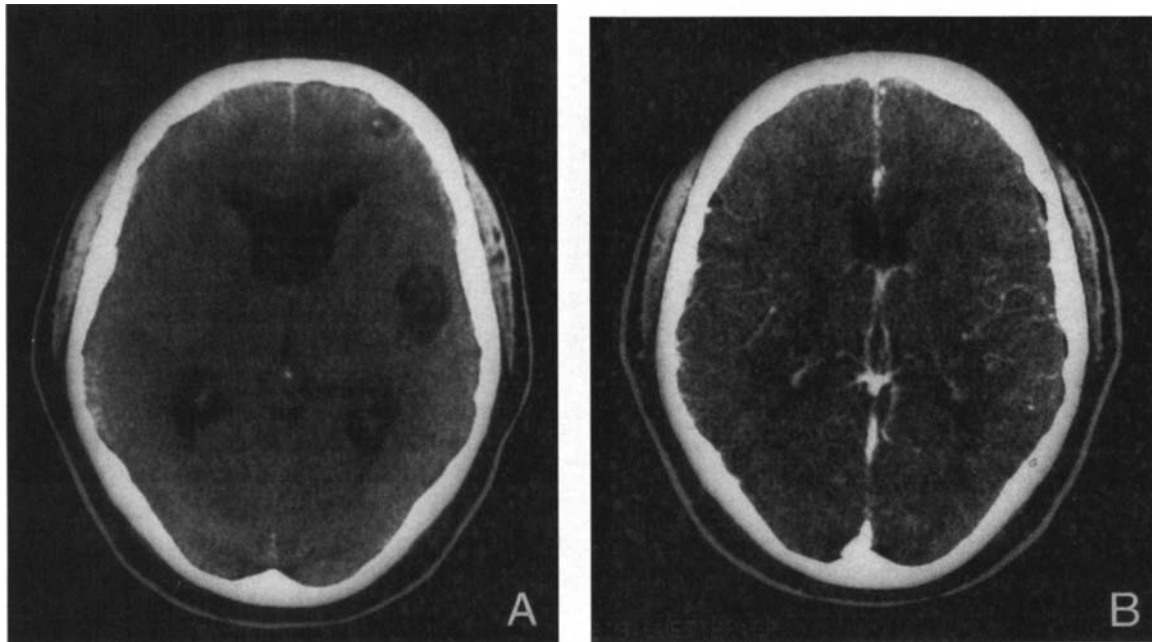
A*, CT scan shows intraventricular and parenchymatous active cysts. *B*, CT scan 11 months later shows resolution of the cyst. The patient was a 46-year-old man who presented with headaches and tonic clonic generalized seizures.
